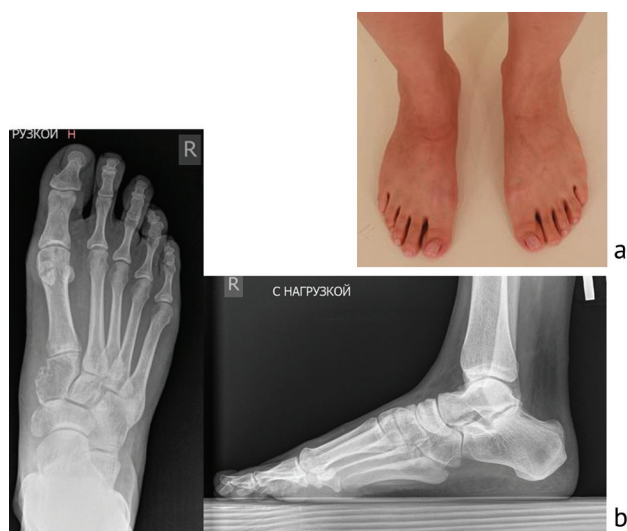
Before surgery: a – photo; b – X-ray pictures in anterior-posterior (AP) and lateral views (demonstrating an osteolytic lesion of the medial cuneiform)
